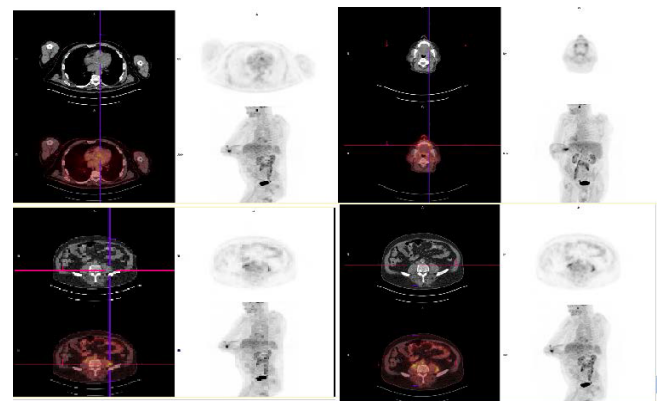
18F- FDG PET/ CT : Hypermetabolism at psoas muscle in bilateral way and extended on the left from L2 to iliopsoas muscle and on the right from L2 to L5 (SUV max 8 g / ml), the L3-L4 vertebrae (SUV max 7 g / ml), maxillary and finally at the aortic valve.
